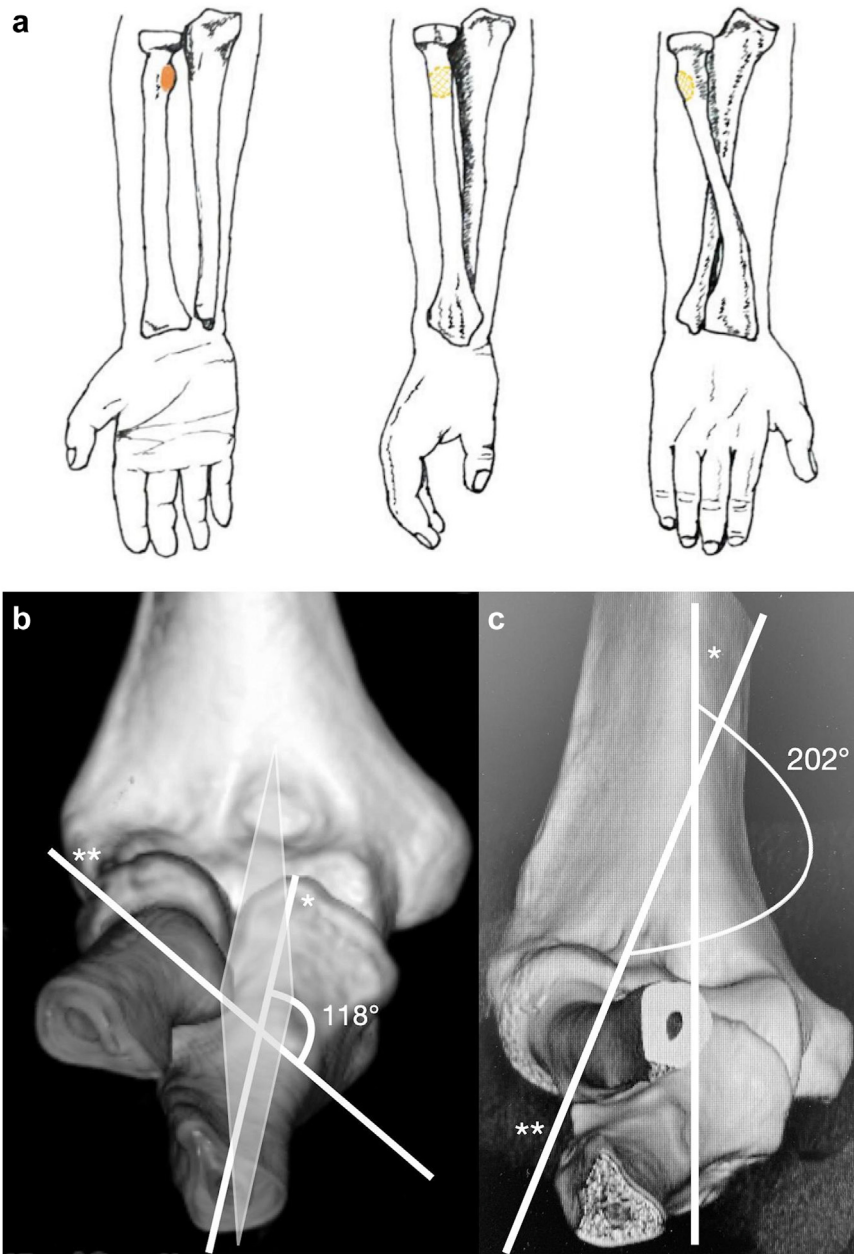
(a) Location of the bicipital tuberosity: at an average 42° from the coronal plane with the forearm in full supination (anterior position); at an average 127° with the forearm in neutral rotation (posteromedial position); and at an average 202° from the coronal plane with the forearm in full pronation (posterolateral position). (b) Three-dimensional CT reconstruction: the angular position of the bicipital tuberosity defined between the line passing through the coronal plane (*) and the line passing through the center of bicipital tuberosity (). The ulna is assumed to be the 0° point on the coronal plane. In this case, the CT was carried out with the forearm in neutral rotation (118°). (c) Three-dimensional CT reconstruction: in this case, the CT was carried out with the forearm in full pronation (202°). CT, computed tomography.
